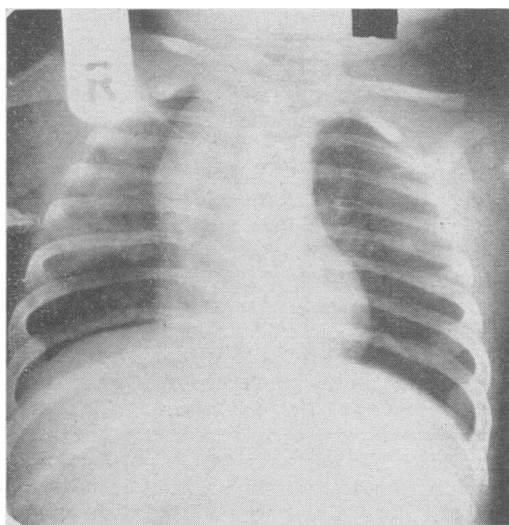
Age 6 months: Chest X-ray after 18 weeks' treatment.
